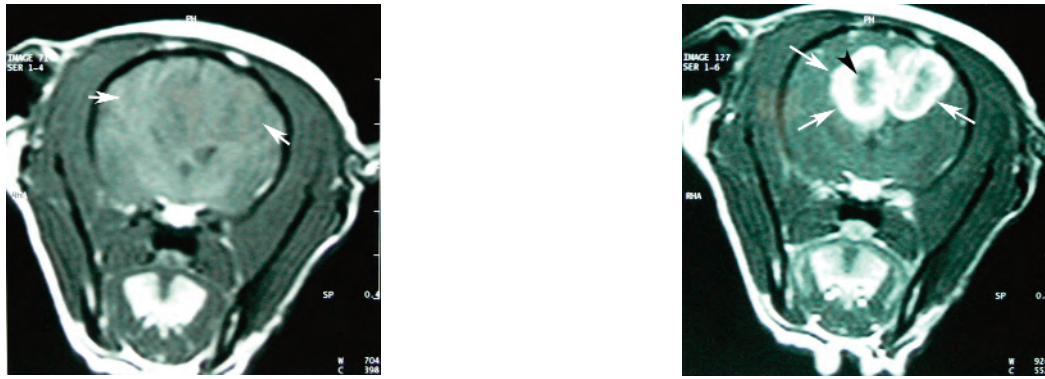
Metastatic tumor with 4-mm midline shift in transverse MR images (case 21 in the Table). Hypointense mass in T1W image (white arrows) (a) and post-contrast T1W image (b). Note the intense contrast enhancement and central necrosis (black arrowhead).
